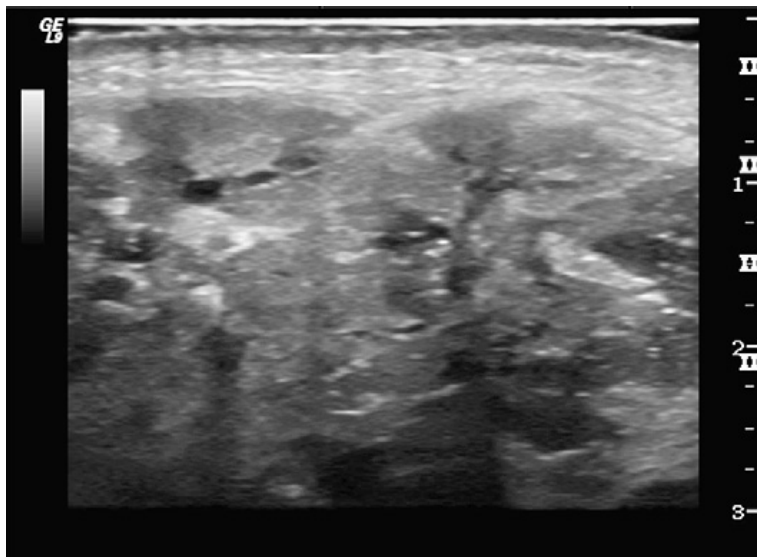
Longitudinal ultrasound of a parotid gland: Unilateral heteroechogenic aspect of the parenchyma with duct dilatation and swelling of the gland.(Philips Katz et al.)
